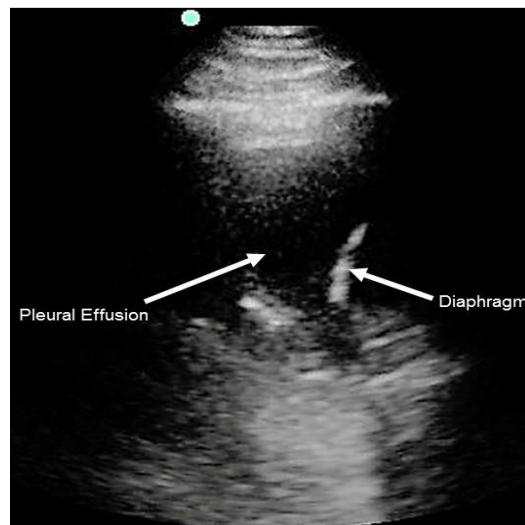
Ultrasound appearance of left-sided, moderate sized, simple effusion.
